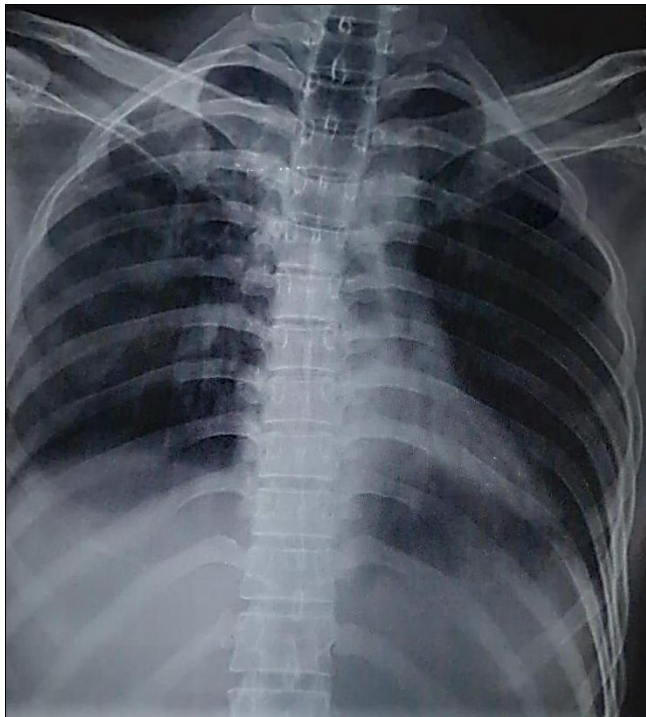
Chest X-ray (AP view) showing bilateral non-homogeneous patchy infiltrates predominantly involving lower zones
